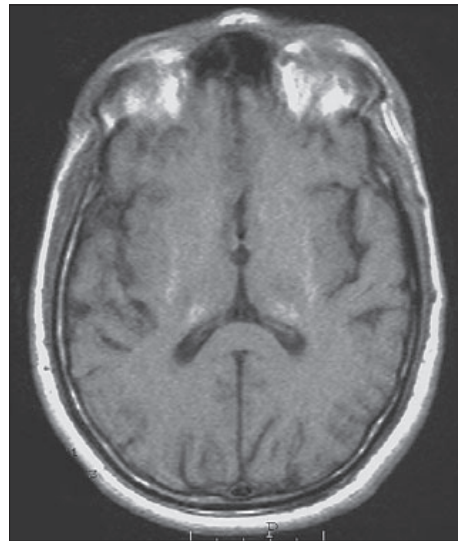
MRI of the brain – T2 weighting – periventricular and subcortical calcifications.
